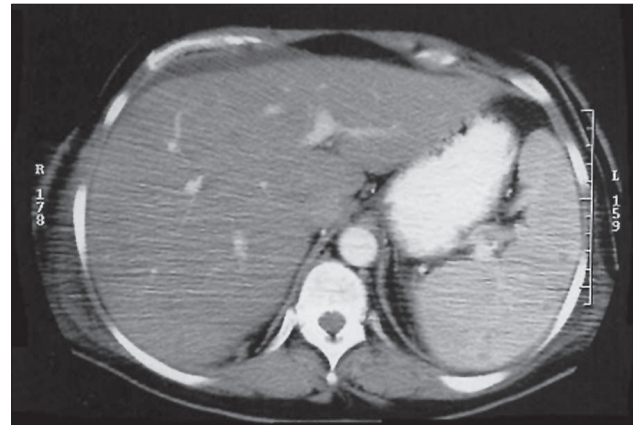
Abdominal CT showing multiple hypodense splenic lesions of which the largest was 8 mm in diameter.
